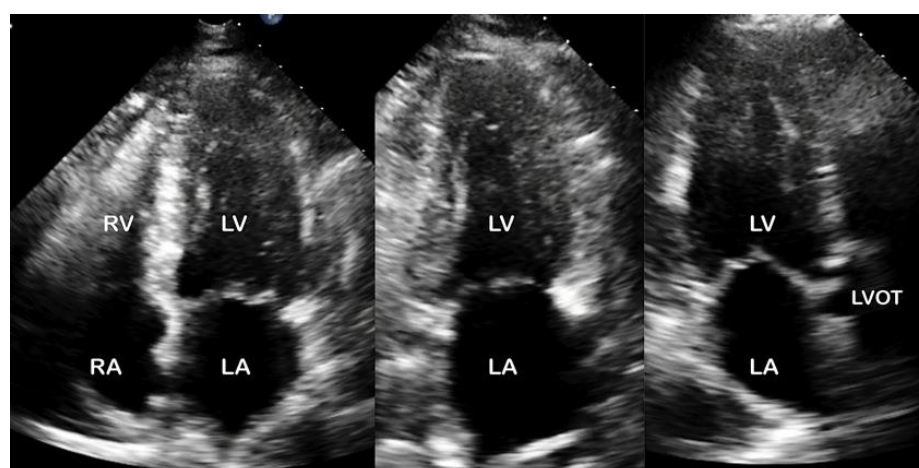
An example of apical 4-chamber (left), 2-chamber (middle) and 3-chamber (right) views on trans-thoracic Echocardiography.
